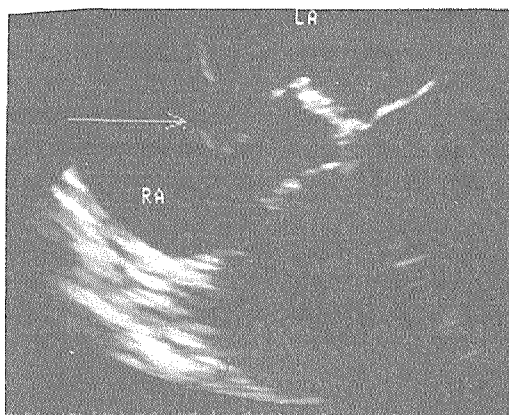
Transesophageal image of an atrial septal aneurysm (arrow). LA = left atrium, RA = right atrium.
